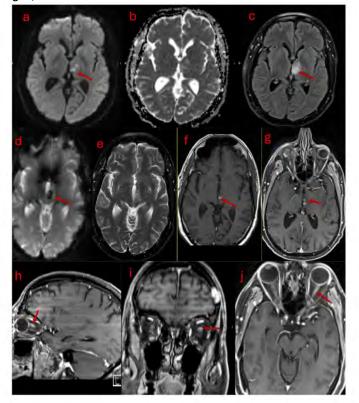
MRI with contrast shows an ill-defined, mildly expansile, T2/FLAIR hyperintense lesion with heterogeneous enhancement (g) and central hemorrhage (d and f) within the left thalamus and medial superior left midbrain. The lesion displays mild diffusion restriction (a and b). There is minimal enhancement observed along the left optic nerve pathway (h, i, and j). Incidental finding of a mildly expansile, avidly enhancing intraosseous lesion in the diploic region of the left frontal bone (j), likely representing an intraosseous hemangioma.
